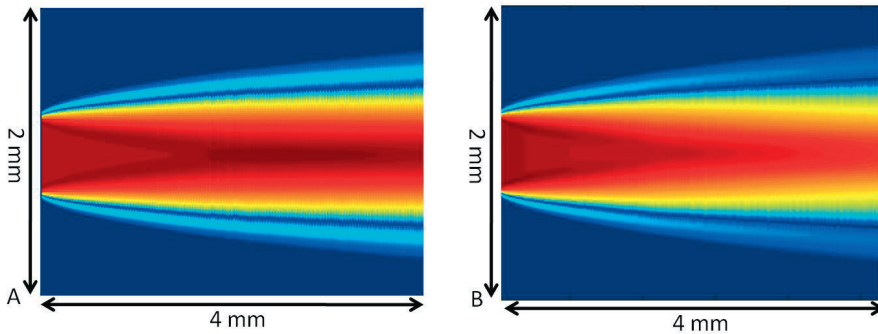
Lateral pressure distribution of a high frequency ( $f = 40$  MHz,  $\text{diam.} = 0.5$  mm) ultrasound pulse generated by a transducer similar to that applied in the present experimental studies, as it propagates through A. a non-attenuating media ( $\rho = 1000$  kg/m<sup>3</sup>) and B. an attenuating media ( $\rho = 1000$  kg/m<sup>3</sup>,  $\alpha = 0.55$  dB/(cm MHz)).
